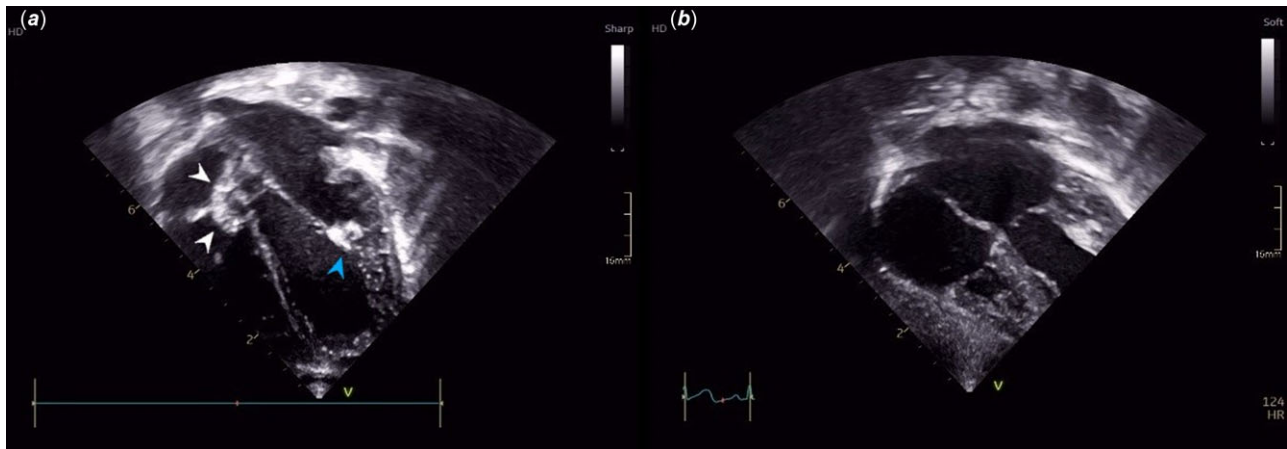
(a) Modified four cavities subcostal ultrasound view showing the atrial thrombus adherent to the interatrial wall with a flimsy tail across the tricuspid valve (white arrow). Note the smaller thrombus fixed to the mitral valve apparatus (blue arrow). (b) Postoperative transthoracic ultrasound showing complete atrial thrombus removal.
